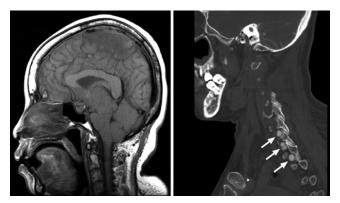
Case 2. Left: Midline sagittal T1-weighted MRI study obtained at presentation showing posterior fossa crowding with pontine flattening and tonsillar herniation, consistent with intracranial hypotension. Right: Sagittal CTM demonstrating Tarlov cysts (arrows) at C6–7, C7–T1, and T1–2.
